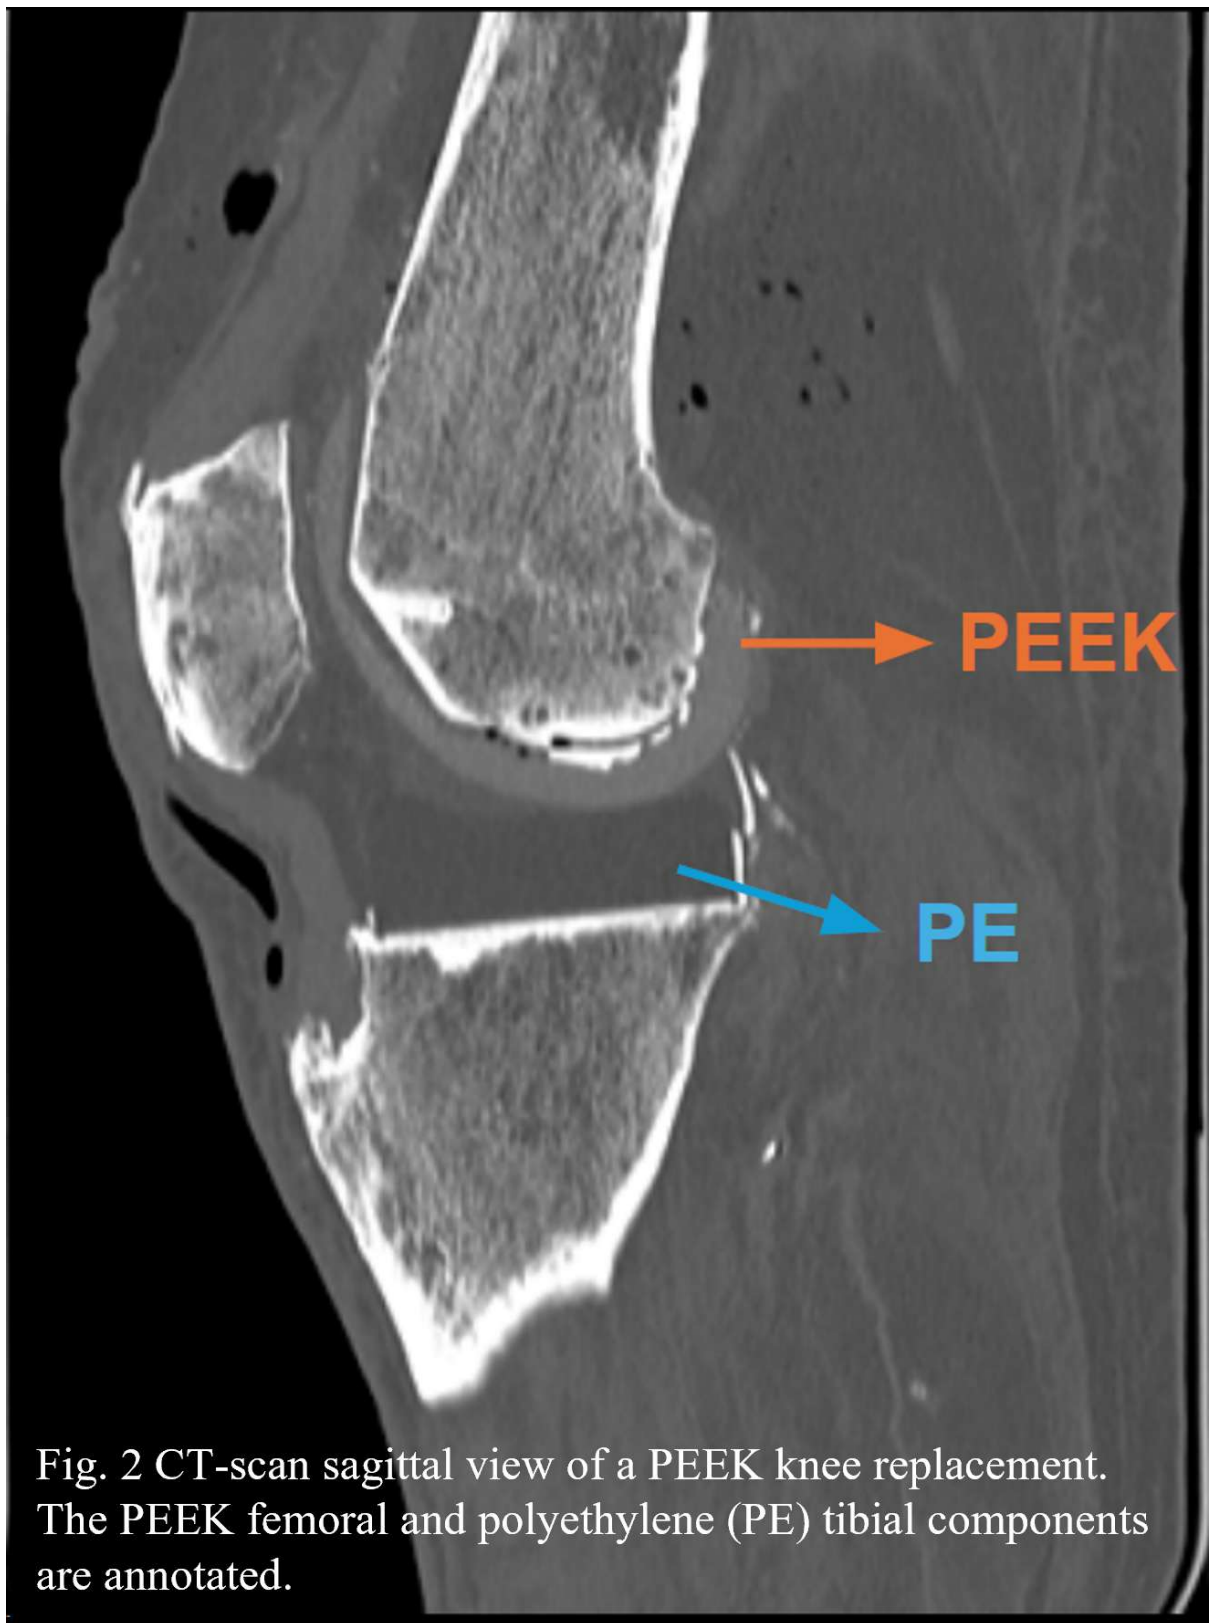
CT-scan sagittal view of a PEEK knee replacement. The PEEK femoral and polyethylene (PE) tibial components are annotated.
